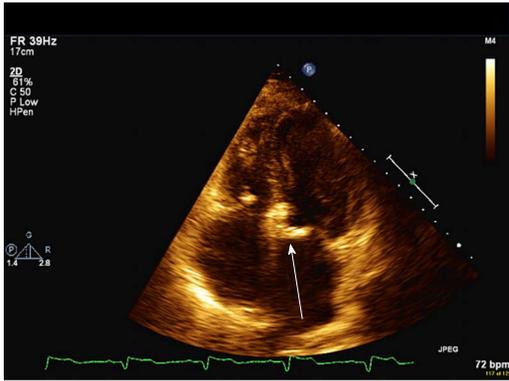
Apical four chamber view of mitral annular calcification (arrow).
